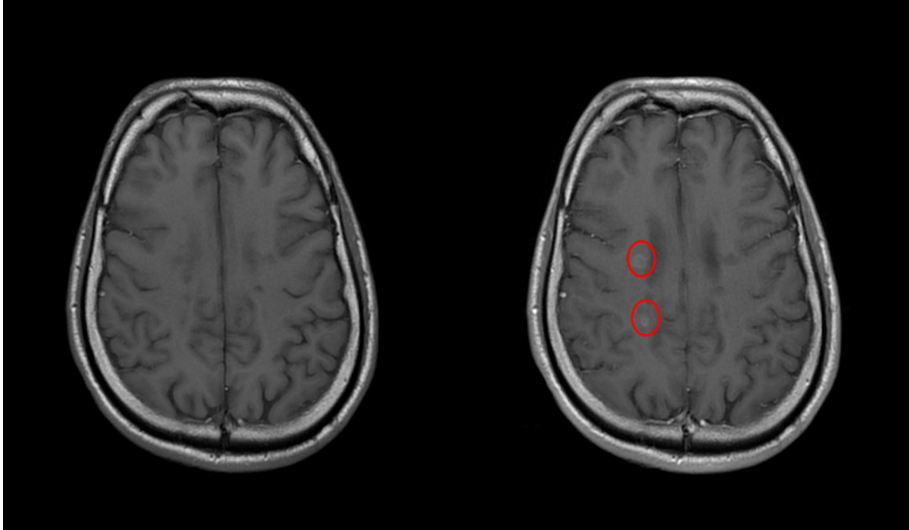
On the left side, a view of a pre-contrast T1 weighted MRI. On the right side, the T1w post-contrast MRI of the same patient, which showed radiological activity (highlighted by two red circles).
